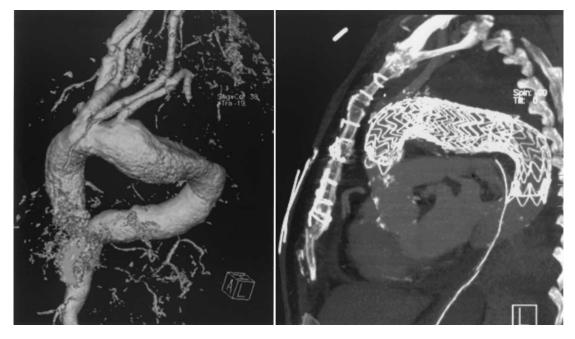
Thoracic arch aneurysm without proximal neck (*left*) and postoperative spiral CT reconstruction showing the position of the 2 endoprostheses in the aortic arch (*right*).
